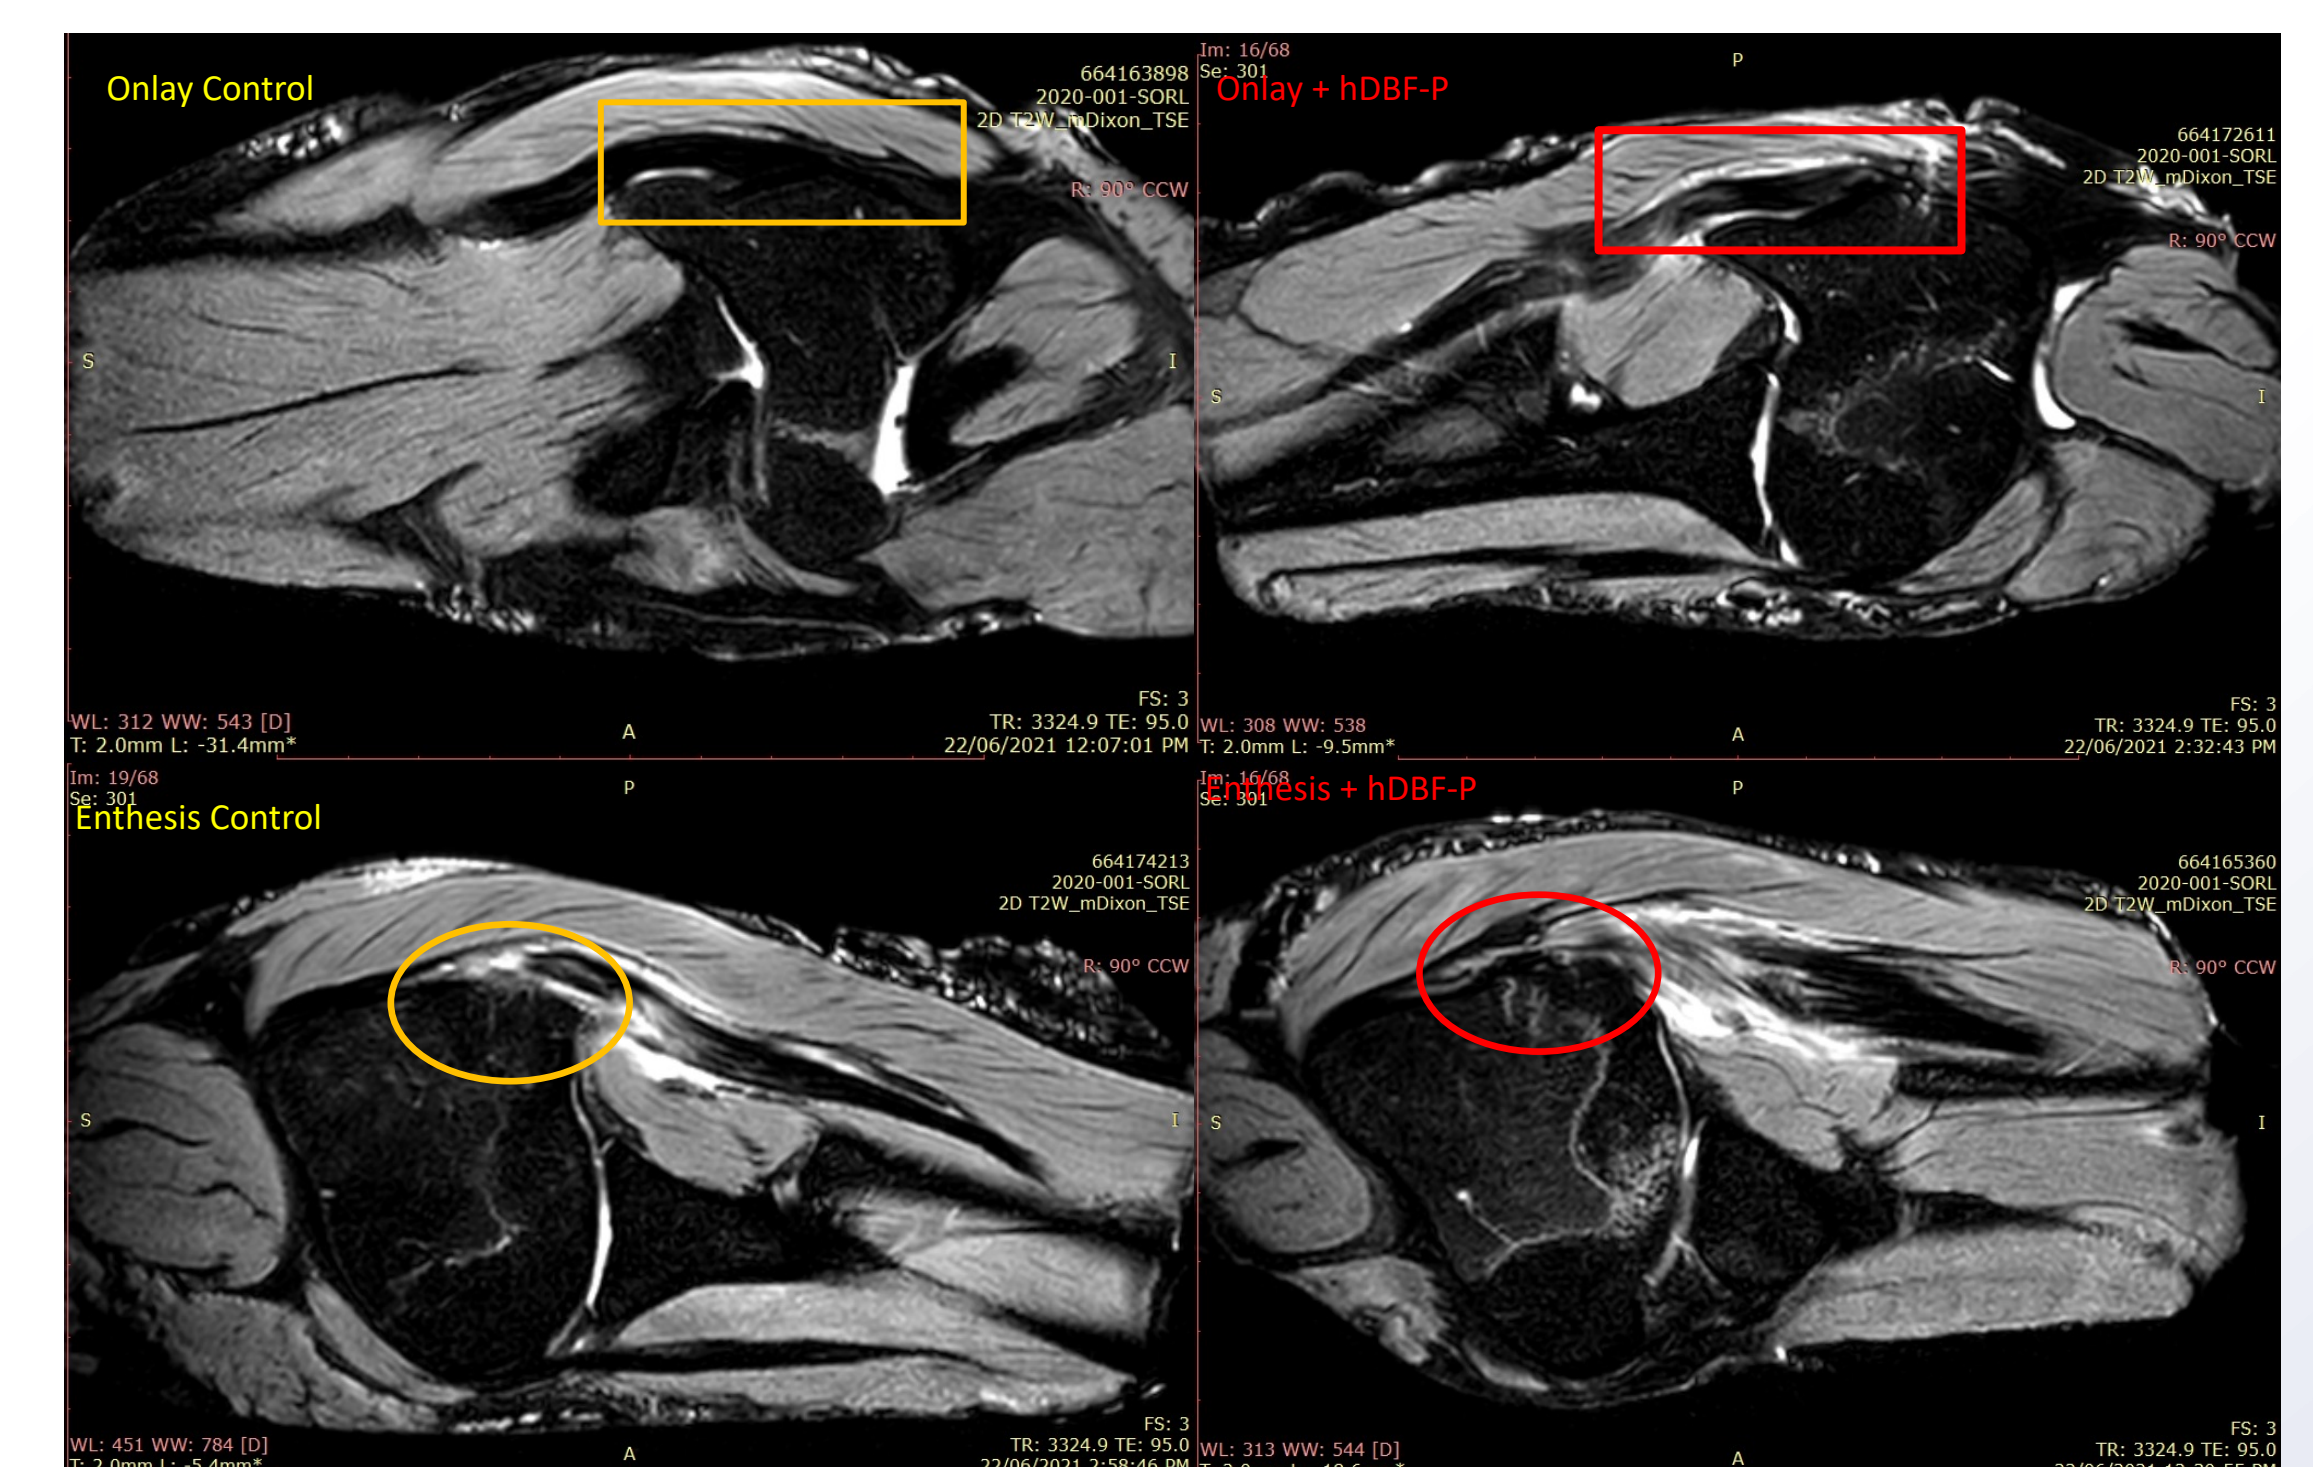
T2 MRI at 12 weeks for the Onlay Control, Onlay + hDBF-P, Enthesis Control and Enthesis + hDBF-P.
